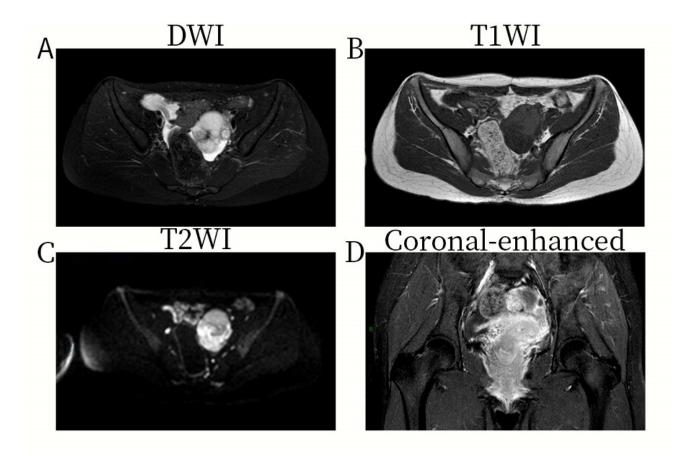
MR images for this case at the time of recurrence. (A) Diffusion-weighted Imaging (DWI) shows a high signal. (B) T1 Weighted Imaging (T1WI) shows a slightly lower signal. (C) T2 Weighted Imaging (T2WI) shows an enhanced signal. (D) The enhancement scan reveals a solid portion and significant enhancement of the separation.
